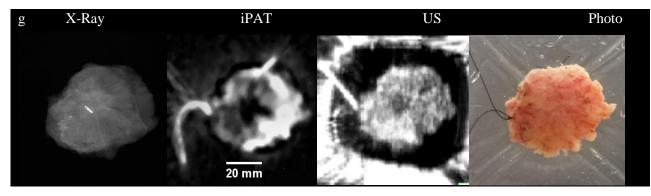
(a) Bilateral DCE-MRI (left) and T1w pre-contrast without fat suppression (right) in axial view showing biopsy confirmed 13 mm IDC in the outer right breast (dashed box) as well as yellow orientation arrows indicating the anterior (A) and medial (M) directions. (b) Coronal view showing the same lesion (dashed box) along with orientation arrows indicating the superior (S) and medial (M) directions. The Figure 4.6(b) orientation is then maintained throughout the rest of Figure 4.6. (c) Selected 1 mm-thick slices continuing in coronal view using T1w pre-contrast acquisition without fat subtraction showing tumor region coinciding with fibro-glandular tissue, which makes the tumour margins difficult to delineate (dashed box). (d) Same coronal slices as in (c) but with a DCE-MRI acquisition clearly showing hyper-intense enhancement of tumour making the margins straightforward to identify. (e) 930 nm iPAT slices co-oriented with coronal MRI slices showing hypo-intense tumor (dashed box), along with clearly contrasting margins. The yellow arrows indicate area of "shadowing artefact" (f) 6.6 MHz iPAT-coregistered US slices demonstrating a centrally located hypo-intense mass (dashed box). (g) X-ray, photograph as well as selected zoomed-in iPAT and US slices taken from the stacks in (e) and (f) offering better side-by-side comparison of detected disease extent as well as visualization of the superior (short) and lateral (long) orientation sutures. Note the I-125 localization seed clearly visible in the X-ray transmission image as embedded inside the stellate tumour. The seed is also visible as hyper-intense in the iPAT results of Figure (e) (red arrow) although the limited resolution makes its delineation more challenging. The seed's location within the tumour was confirmed by pathology.
